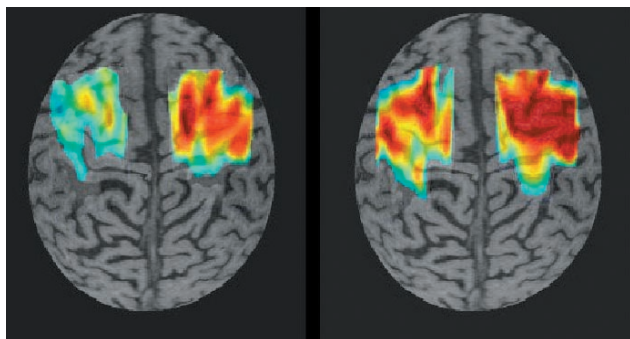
MRI co-registration of pharyngeal motor map in a dysphagic stroke patient after left basal ganglia infarct. Topographic maps were acquired before and 1 hour post-pharyngeal stimulation. Stimuli were applied to individual points on a scalp grid matrix and the responses recorded. A scalp map representing the areas of response for pharynx was then generated and co-registered anatomically with the patient's motor cortices using MRI. After stroke, most of the pharyngeal representation is on the undamaged (right) hemisphere. The greatest changes are also seen in the intact hemisphere after pharyngeal stimulation (Reference 22).
